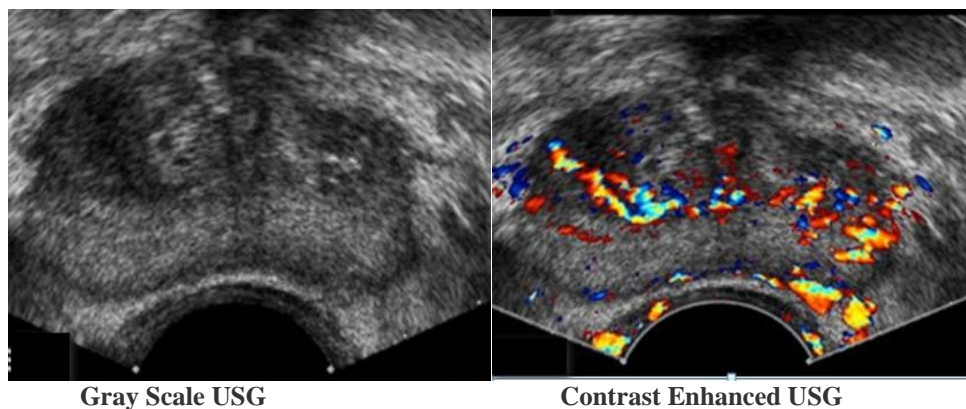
A. Conventional gray scale transverse image does not show any suspicious lesion. in the left base of the prostate B. Only contrast-enhanced colour Doppler transverse image shows increased flow associated with the cancer
